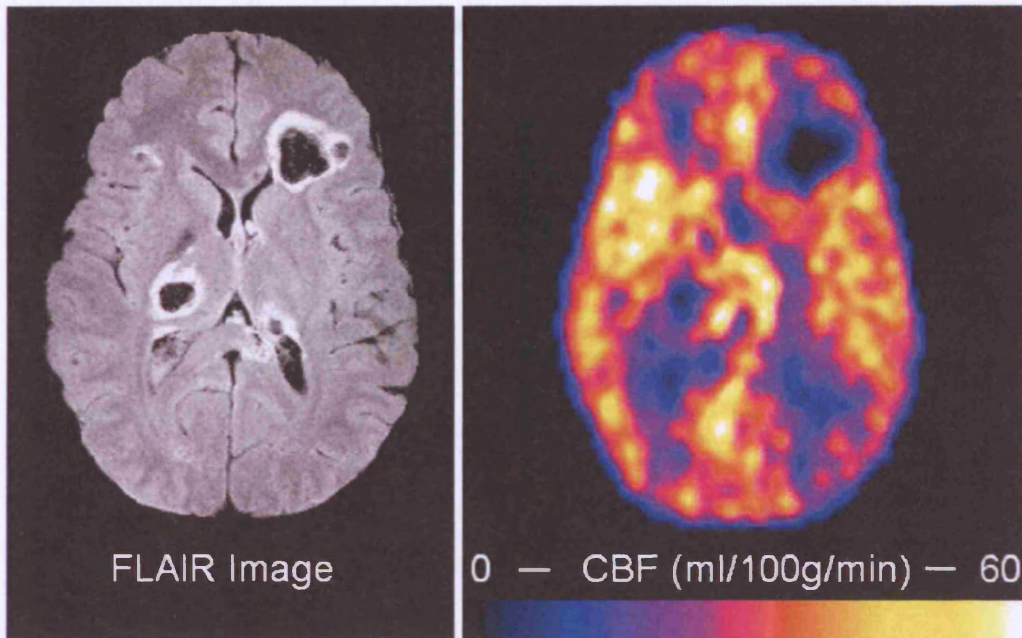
Coregistered FLAIR and ^{15}O -PET CBF map showing significant pericontusional hypoperfusion extending beyond areas of pericontusional hyperintensity visible on the FLAIR image.
